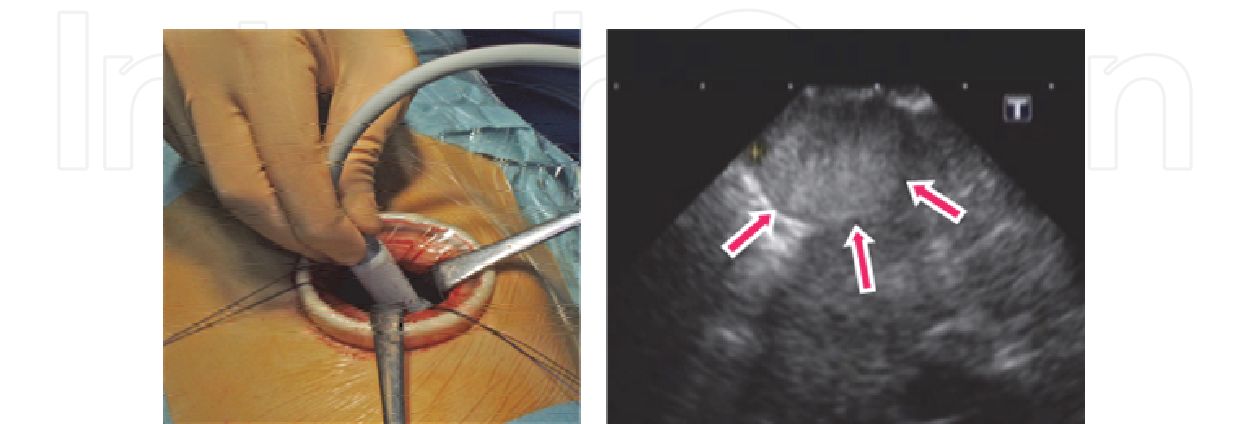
Identification of the tumour using ultrasound.
